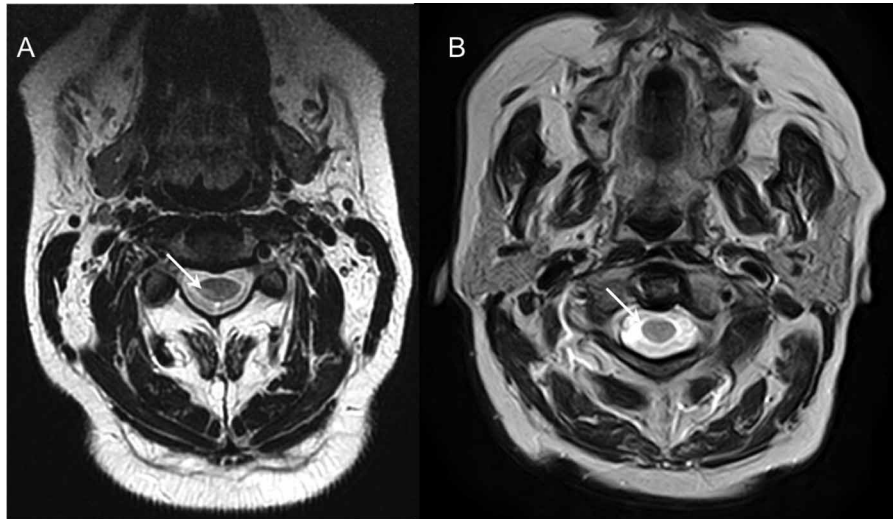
(A) Axial T2-weighted fast spin-echo (T2-FSE) spinal cord MRI showing the lesion involving the posterior columns (arrow) of the cervical spinal cord between C2 and C3. (B) Axial T2-weighted spinal cord MRI after 6 months of copper supplementation.
